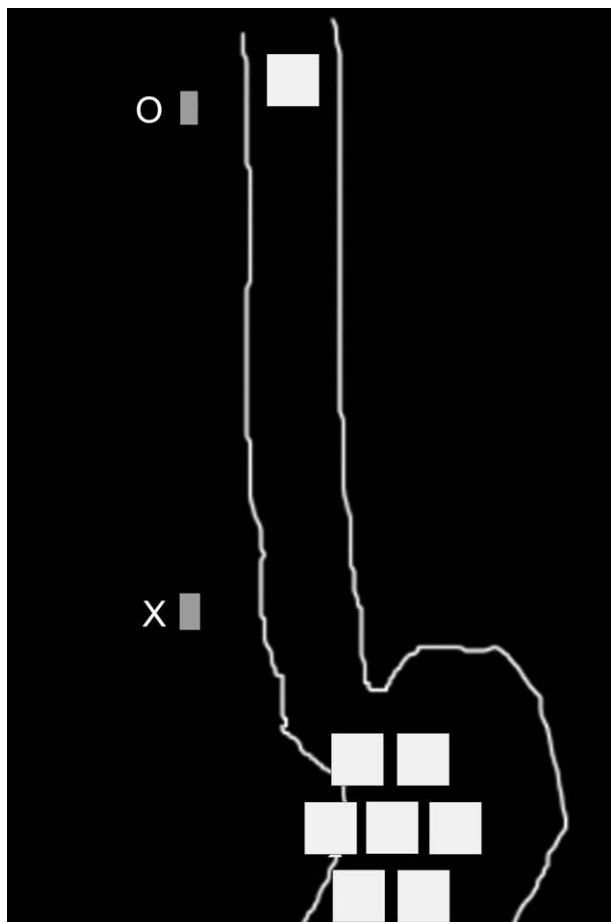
Regions of interest (ROIs) drawn in the scintigraphic images based on oropharynx (O) and xiphoid (X) anatomical landmarks. This procedure was adopted to provide comparative analyses between scintigraphy and ACB.
